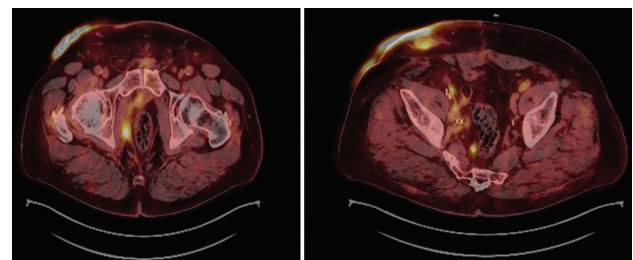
Positron emission tomography-computed tomography images obtained prior to the initiation of enfortumab vedotin therapy
